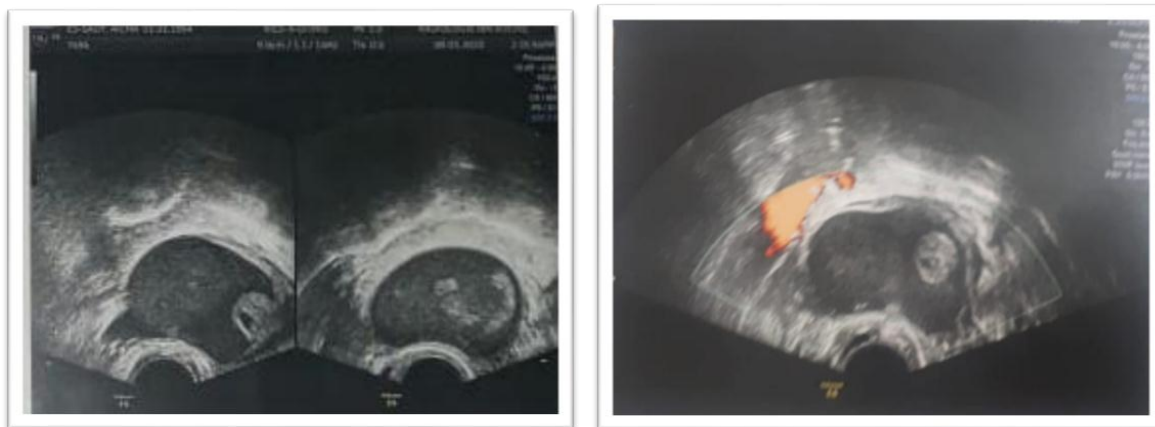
Left solido-cystic ovarian mass, not vascularized on Doppler.
